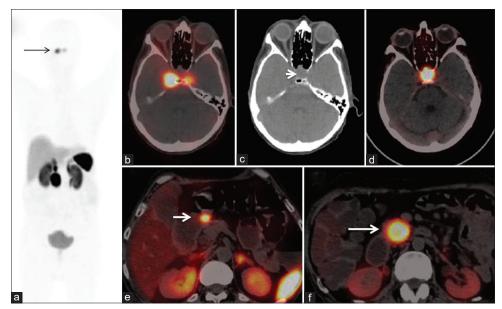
Maximum intensity projection image (black arrow, a) showing 2 focal uptake on either side of brain on either side of mid line, sees as uptake in bilateral cavernous sinus region on trans-axial FDG PET/CT image (b) with no significant corresponding abnormality but only a solitary pituitary lesion on trans-axial CT (c). Repeated PET/CT acquired after correction of blood glucose shows single uptake co-registered with pituitary lesion on fused PET/CT image (d). Additionally DOTA-TOC avid lesion noted in distal stomach and head of pancreas on fused PET/CT image of mid-abdomen (white arrows, e and f) respectively-suggestive of Gastrinoma
